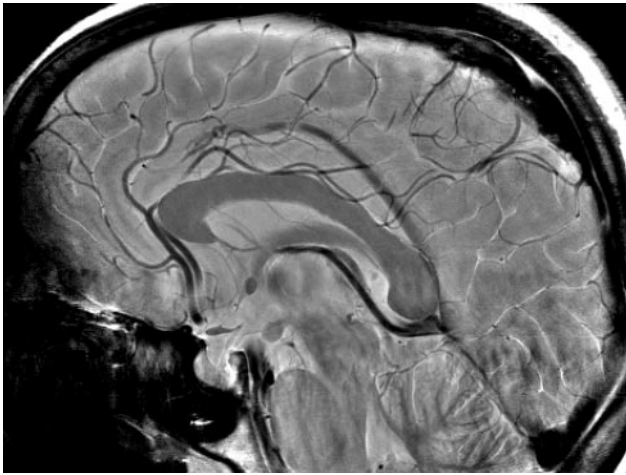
Magnetic susceptibility effects at 7T magnetic field strength. Sagittal T2-weighted image of the brain at 7T showing highly visible vessels because of magnetic susceptibility effects that highlight the presence of hemoglobin. High-resolution and high-field-strength MRI may be particularly well suited for evaluating both acute and chronic hemorrhage because of the presence of iron. (Image courtesy of Lawrence Wald, PhD, Massachusetts General Hospital, HST AA Martinos Center.)
